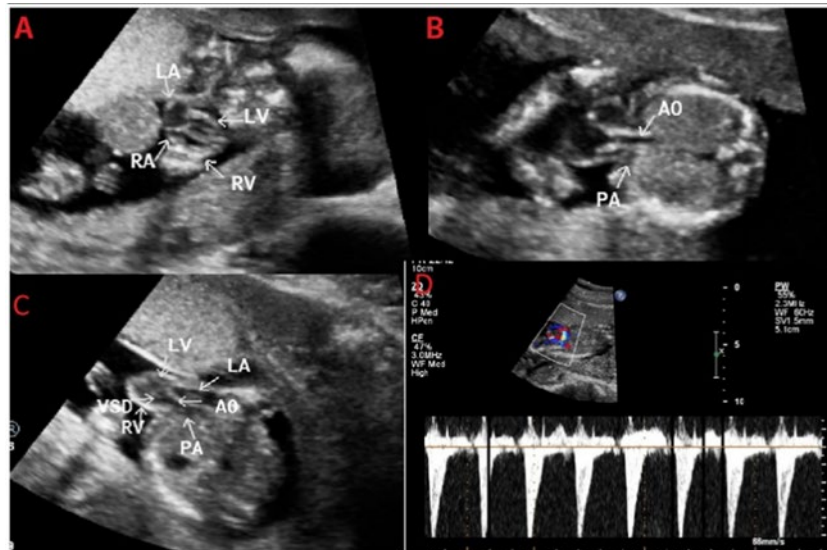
Fetal Echocardiography of isolated thoracic Ectopia Cordis (EC): A.4chamber view showing well developed Left Atrium(LA),Right Atrium(RA),Right Ventricle(RV) and Left Ventricles(LV) B and C. Double Outlet Right Ventricle and Ventricular Septal Defect(VSD), small pulmonary artery (PA) and PA branches, aortic overriding, anterior malposition of Aorta (AO) or D-Transposition of Great Arteries., LV: Left Ventricle, LA: Left Atrium. Doppler flow profile: Increased turbulency of ascending aorta exiting from the heart entering toward the body.
